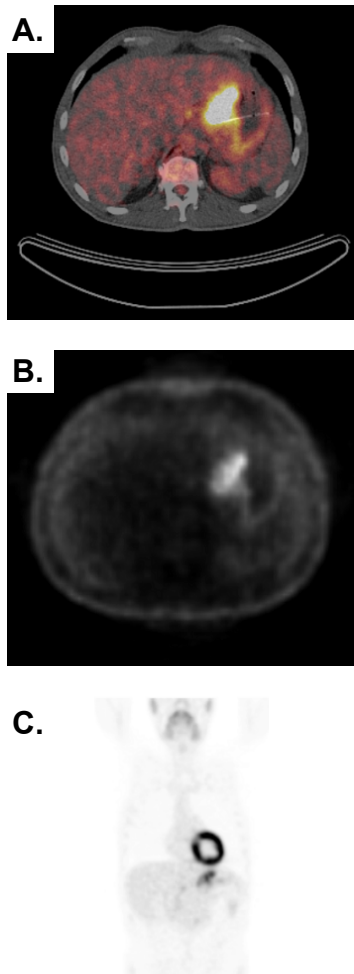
Representative FDG-PET image of a patient with primary gastric cancer without lymph node or distant metastases. A+B. Transversal slides of respectively CT-PET fusion and FDG-PET examinations highlighting pathological FDG-PET uptake in the gastric wall. No lymph node or distant metastases are observed. C. Frontal slide of total body FDG-PET examination with physiological FDG-PET uptake in the myocardium, and pathological uptake in the gastric wall. Again, no lymph node or distant metastases are observed.
